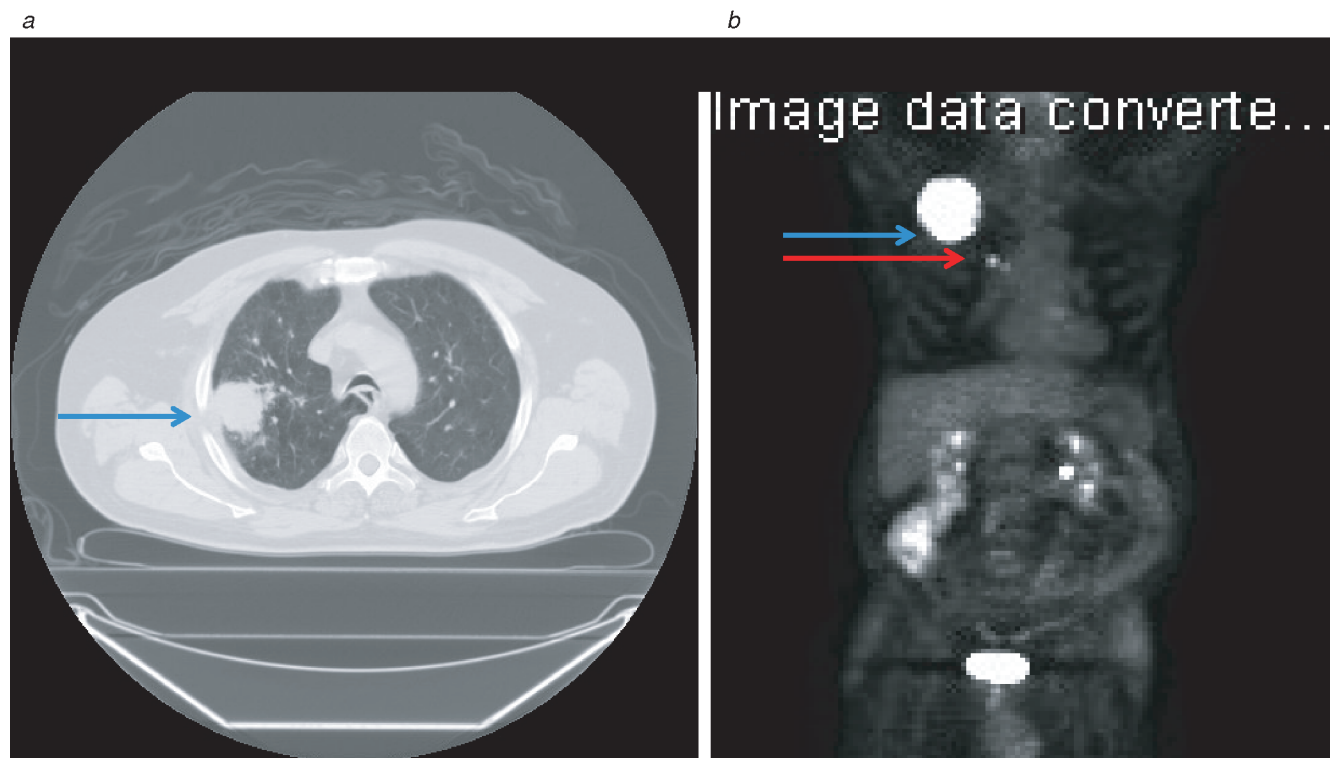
(a) Right upper lobe non-small cell lung cancer on a computed tomographic scan. (b) Positron emission tomographic scan. The blue arrows indicate the primary tumor, and the red arrow indicates the hilar lymph node.
